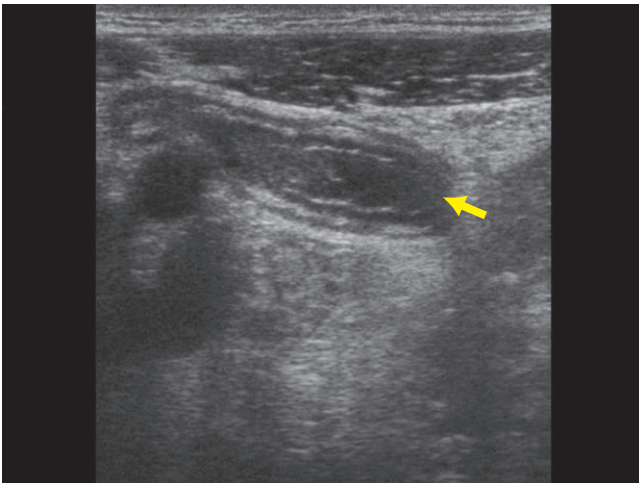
Ultrasound showing fluid-filled blind ending tubular structure (arrow) with surrounding echogenic mesentery fat.
